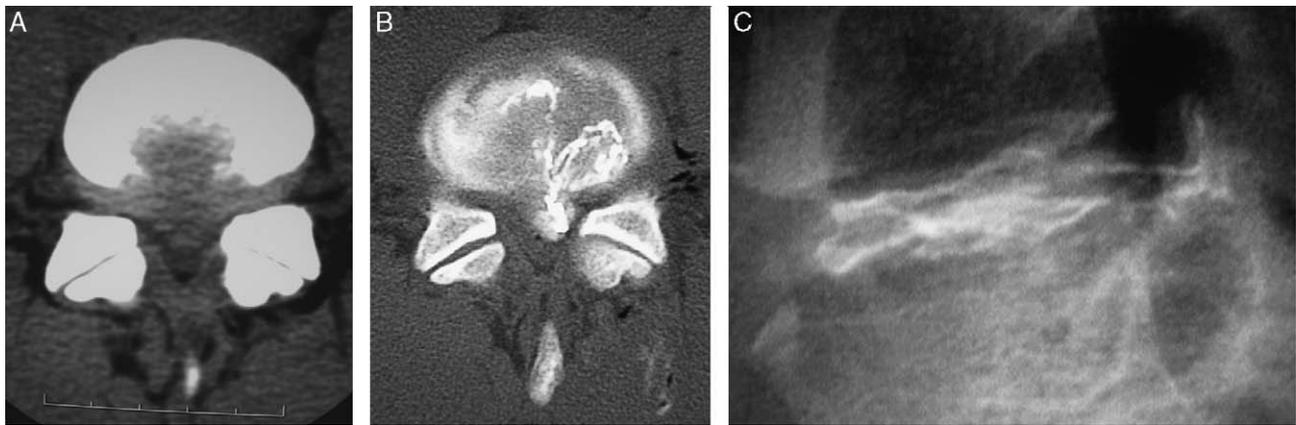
Lumbar disk hernia treated with RGE. A, CT before treatment. B, Disco-CT after treatment, modified windows showing the RGE after the intradiscal fissures and concentrating in the extruded hernia. C, Plain lateral x-rays after treatment showing the RGE in the disk and extruded hernia.
